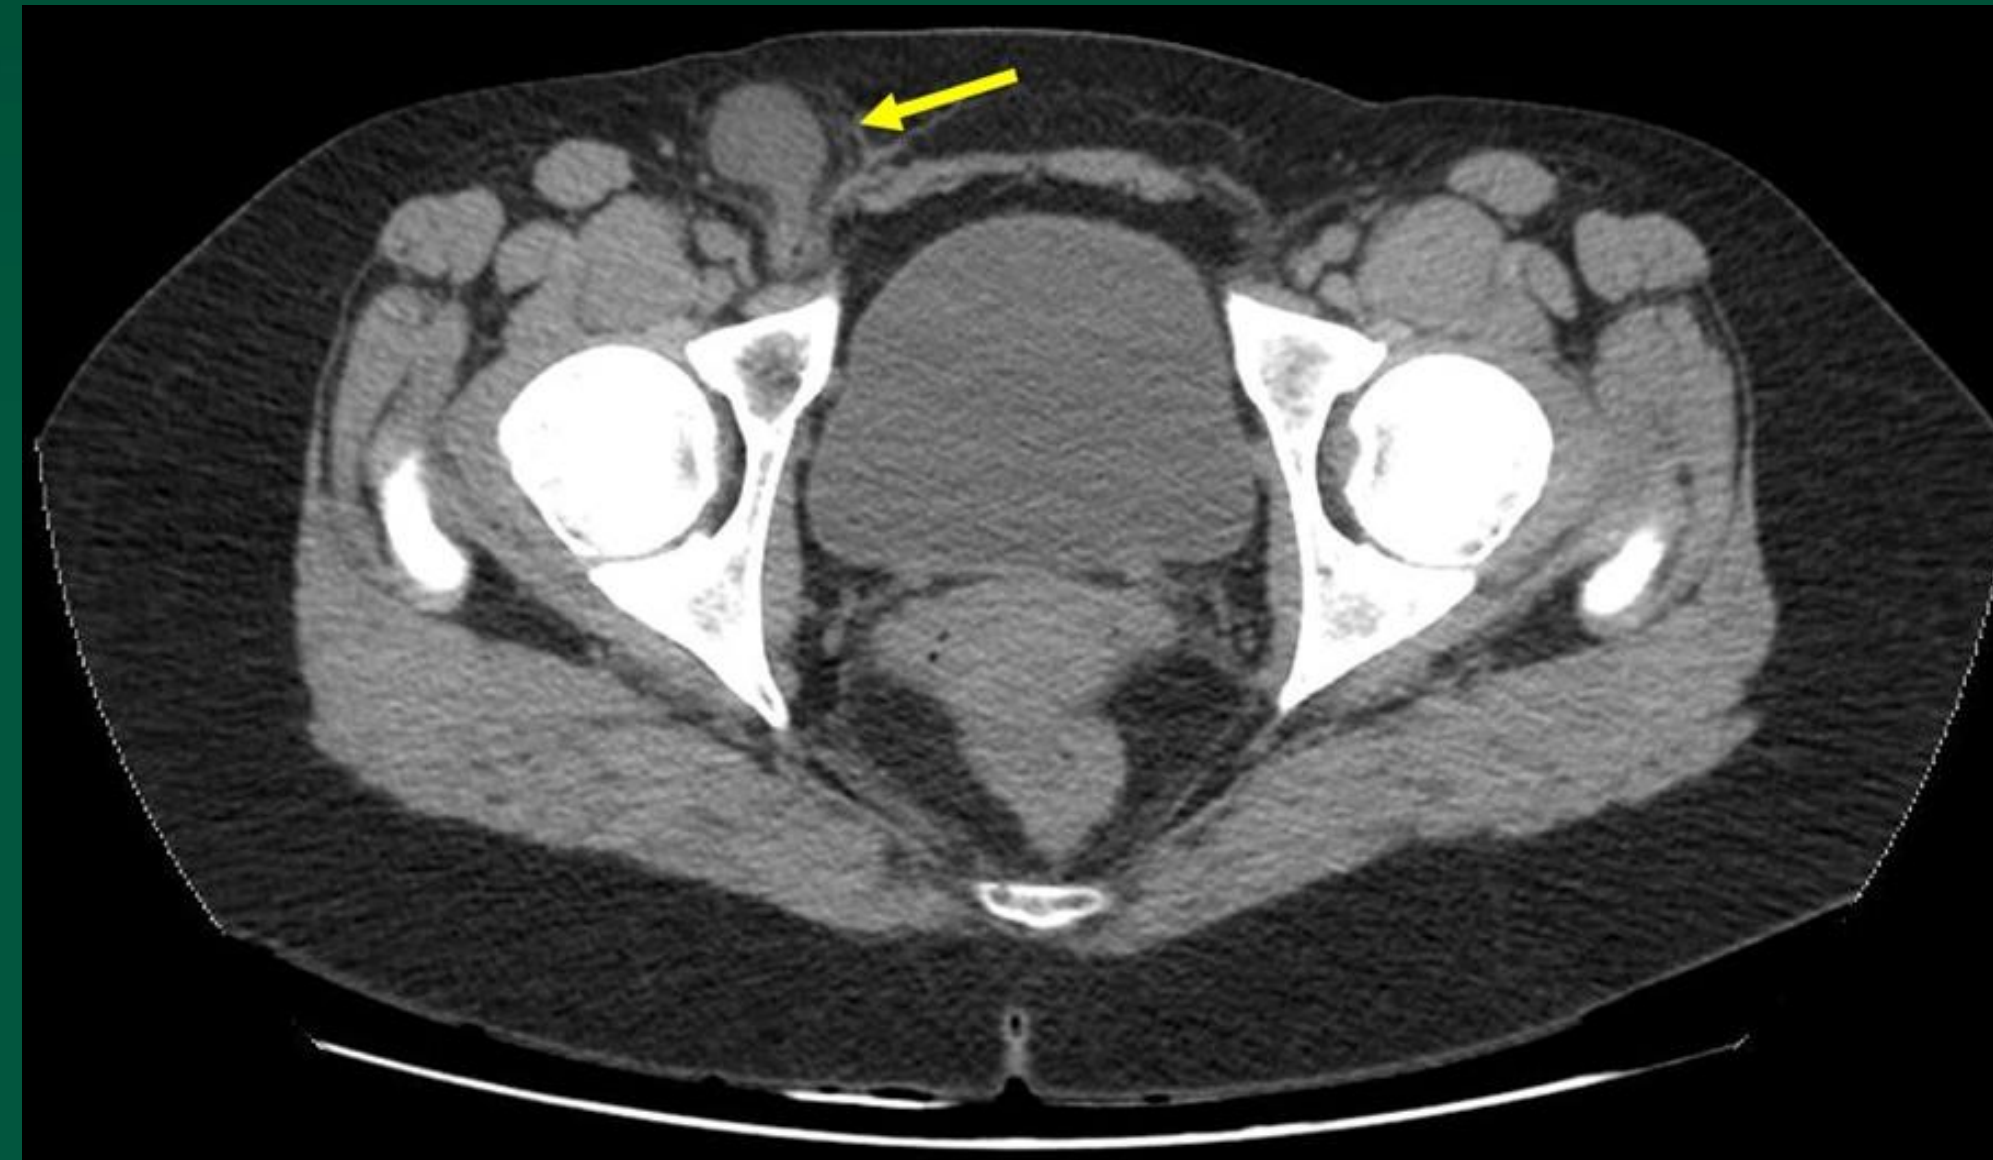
Axial CT showing right femoral hernia
